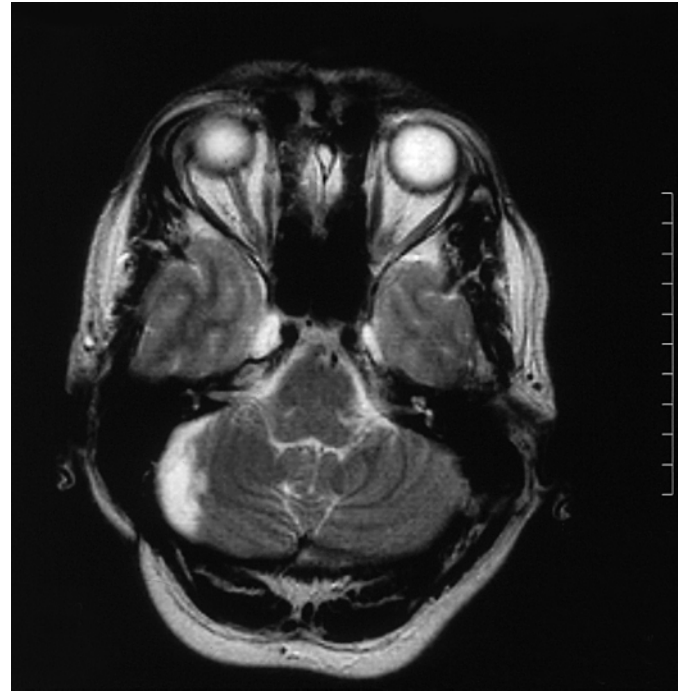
MRI two months after second surgery (T2, slice-thickness 5 mm).
